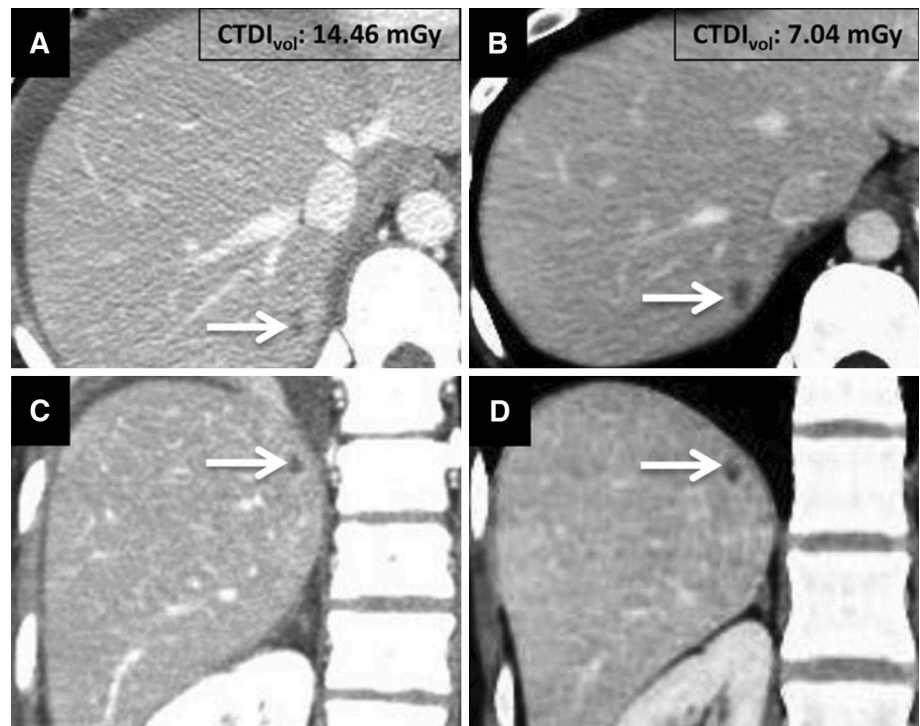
Improved lesion conspicuity with IR despite a decrease in the CT radiation dose. Axial (a) and coronal (c) CECT images reconstructed with FBP show a small hypoattenuating lesion (*arrow*) in segment VII of the liver. The CTDI_{vol} for the study was 14.46 mGy. Follow-up axial (b) and coronal (d) CECT images reconstructed using level 50 % of ASIR (GE Healthcare) show the same lesion. The CTDI_{vol} for the followup study (7.04 mGy) was just under half the radiation dose of the initial study. Note the preservation in diagnostic accuracy of the images, despite a lower radiation dose, when using IR. Also note the different image texture in the IR images compared to FBP
